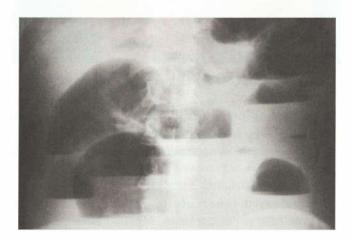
Plain X-ray showing dilated air fluid levels
